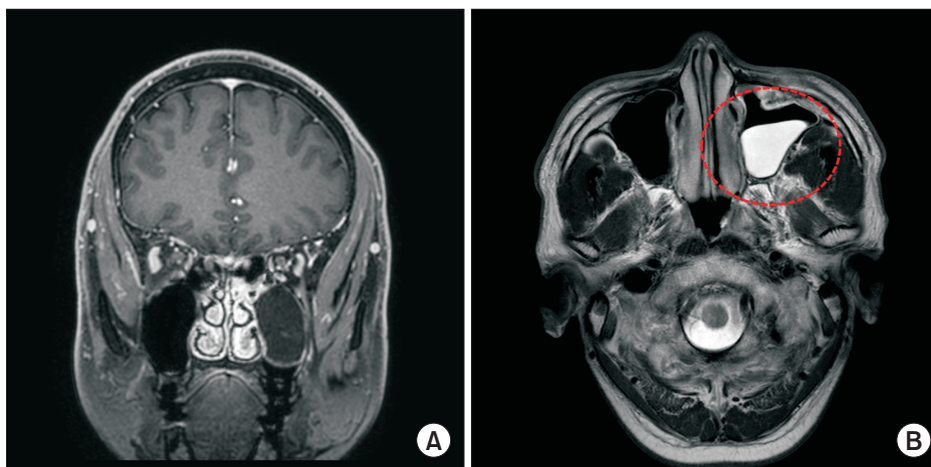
Brain magnetic resonance imaging was obtained on the first visit. The dotted circle shows fluids filling the left maxillary sinus. (A) T1-weighted image. (B) T2-weighted image.
